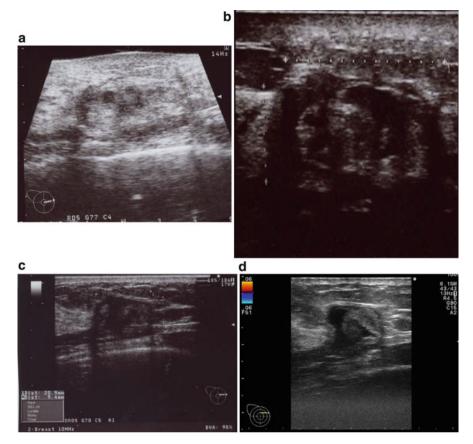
(a) Representative ultrasonography (US) image obtained 1 month after radiofrequency ablation (RFA) showing a 20 mm-sized isoechoic ablation zone. The boundary of the ablation zone showed slightly low echogenicity, and the ablation zone is recognized as an oval shape. (b) US performed 3 months after RFA showing a hypoechoic area around the ablation zone. The boundary of the ablation zone is slightly hyperechoic compared to the surrounding fat tissue. (c) US performed 1 year after RFA revealing that the hypoechoic regions have spread widely and now appear as a lateral shadow. (d) US obtained 5 years after RFA revealing a cyst-like appearance of the ablation zone. Color Doppler US showing the absence of blood flow in the ablation zone. The hyperechoic components within the ablation zone appeared to be fluid, as determined by vibration of the US probe, and subsequent needle biopsy examination showed that the contents were necrotic tissue
